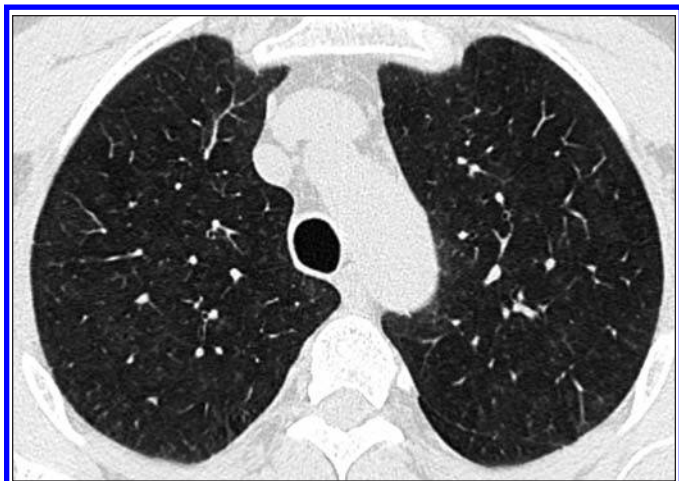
Acute hypersensitivity reaction to calcium sulfate in gypsum exposure. Transverse CT image of chest shows diffuse bilateral upper lobe airspace nodules, reflecting alveolitis without signs of lung fibrosis.
